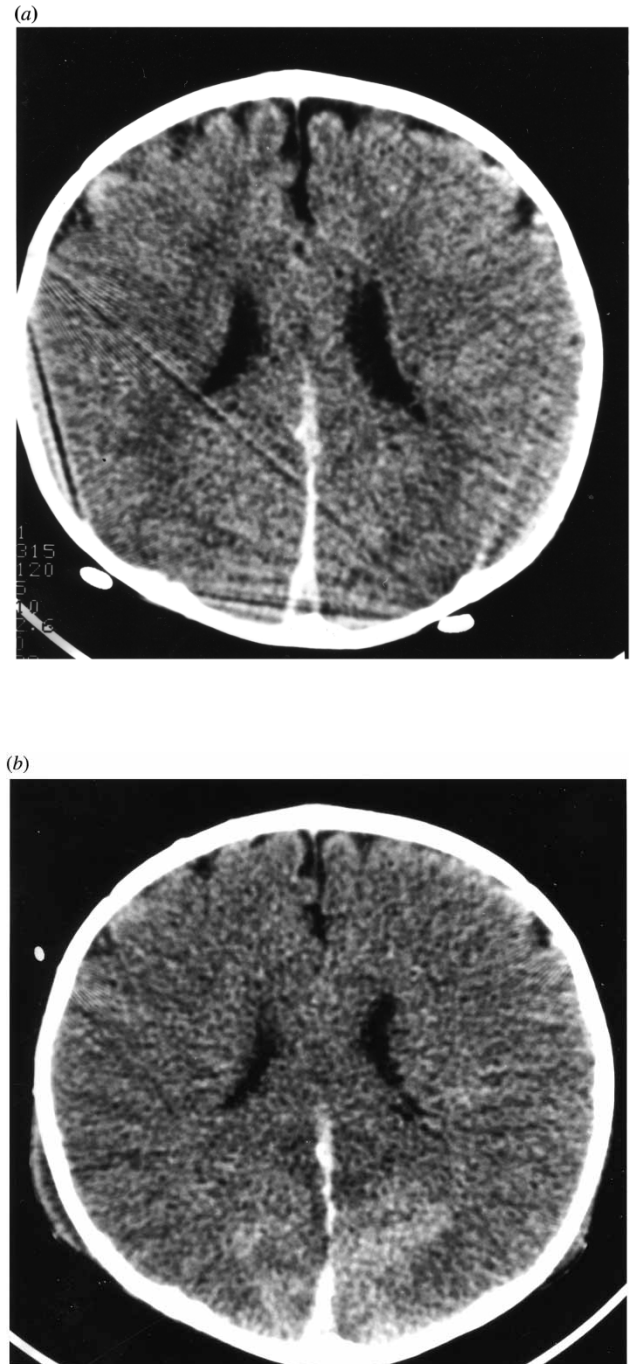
(a) 9 month old male admitted with acute encephalopathy and decerebrate posturing. CT scanning within 16 hours of presentation demonstrates acute bilateral posterior parafalcine subdural haematomas and early cerebral oedema. Note the preservation of cerebral sulci anteriorly. (b) CT scan 5 days later shows static size and appearance of the subdural haematomas. Global cerebral swelling and hypodensity has developed with effacement of the cerebral sulci. The right sided scalp swelling relates to a previously inserted scalp cannula. (c) (opposite page) Follow-up CT scan 2 months later demonstrates end stage hypoxic-ischaemic injury with development of large subdural collections secondary to cerebral atrophy.
